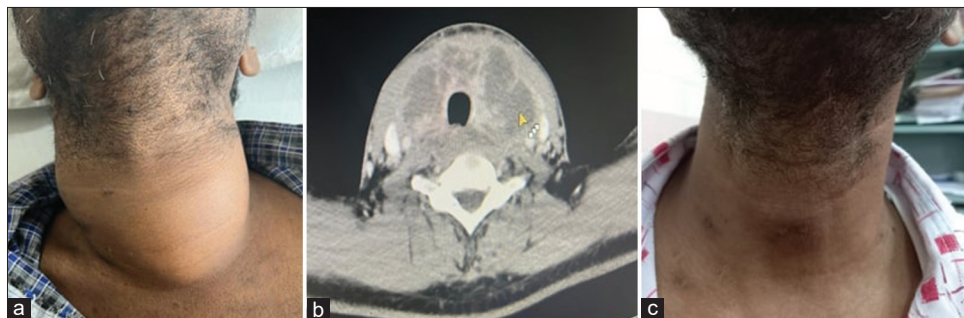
(a) A patient having diffuse painful neck swelling on admission. (b) Contrast-enhanced computed tomography of the neck showing multiple hypodense collections in both lobes of the thyroid and extending to the retropharyngeal space. (c) Resolution of swelling of the same patient after treatment
